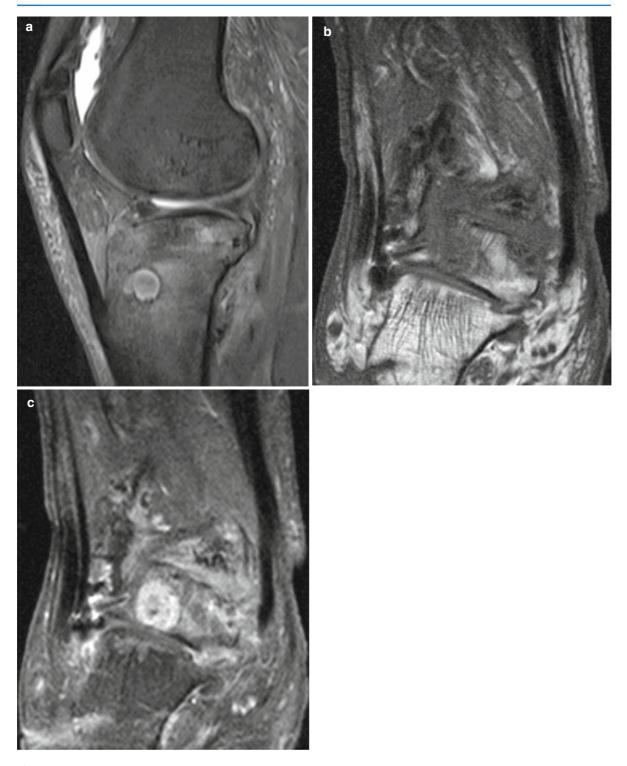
(a) Chronic osteitis: increased signal on MRI. (b, c) Chronic osteitis: increased signal in MRI and uptake of contrast medium in T1 sequences
